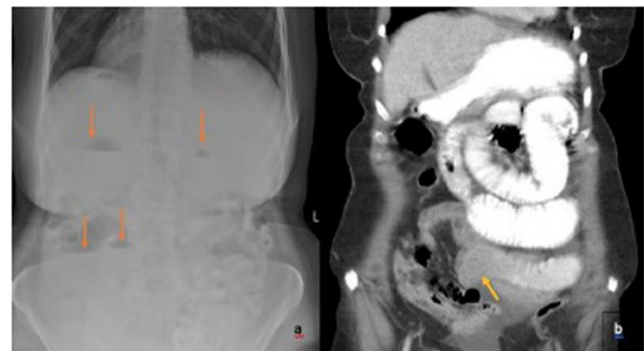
The patient's preoperative abdominal x-ray (A) and ct scan (B) coronal plane. The preoperative standing plain abdominal radiograph shows air-fluid levels in the small intestines, and the CT shows that the bezoar is obstructing the passage of contrast and the proximal loops are dilated.
